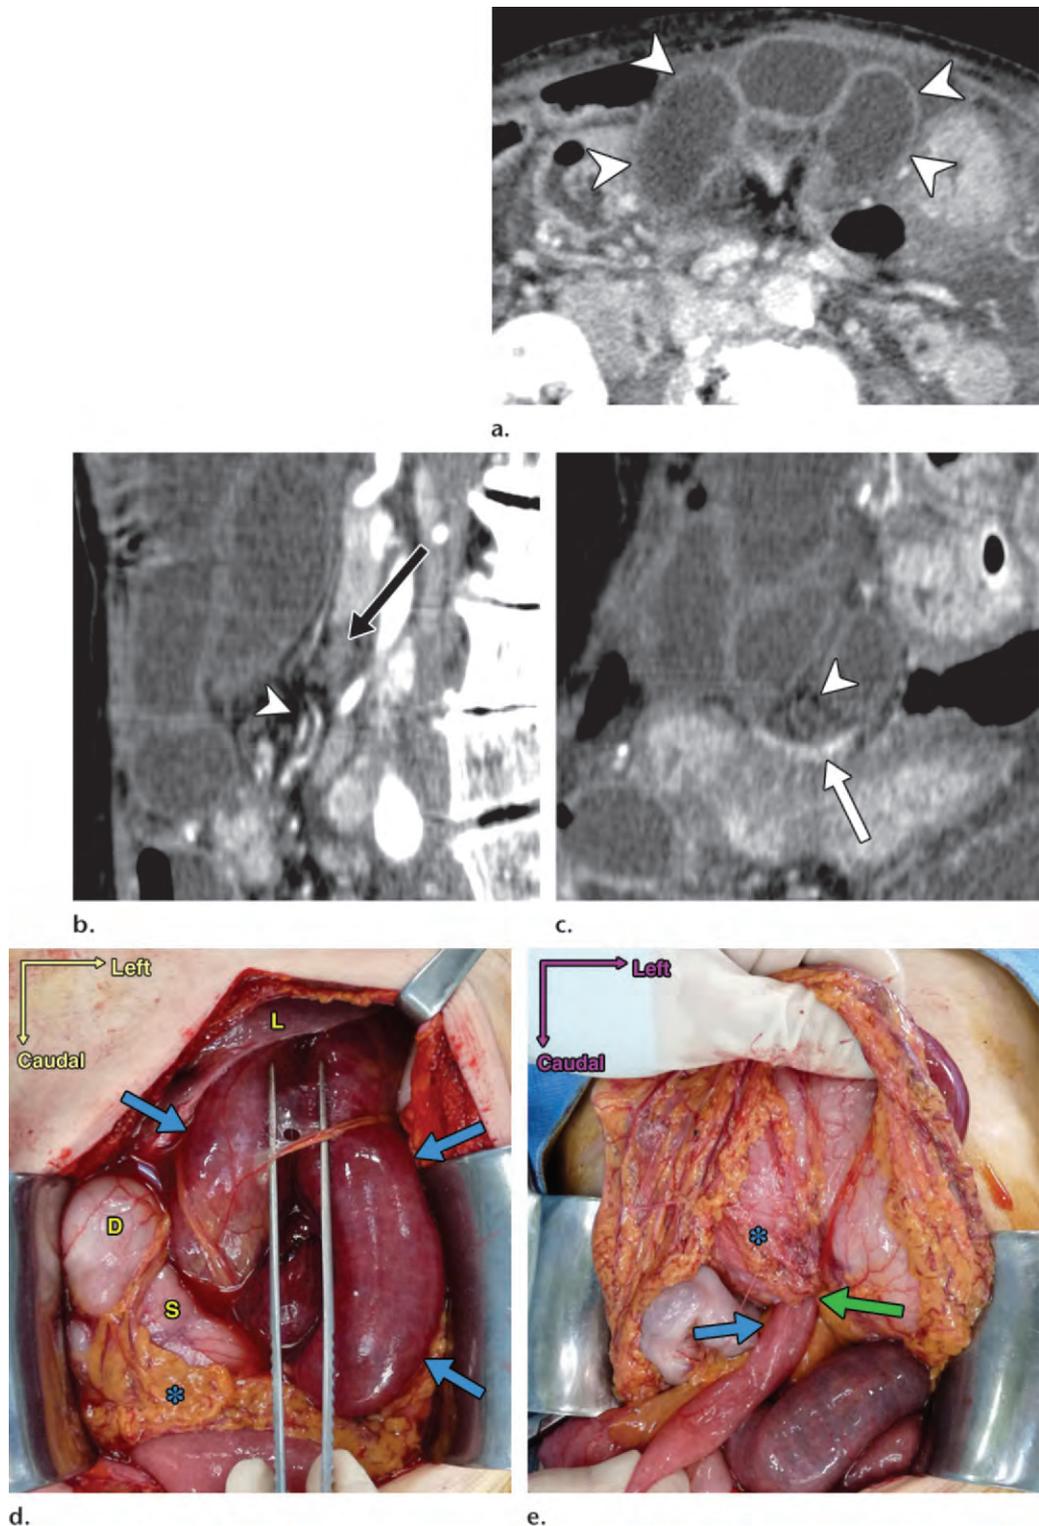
Combined lesser sac hernia through the greater and lesser omenta in a 75-year-old woman who presented with epigastric pain. (a) Axial contrast-enhanced CT image shows closed-loop intestine (arrowheads) in the anterior portion of the peritoneal cavity. (b, c) Oblique MPR CT images show the hernia orifice (arrowhead) below the transverse colon (black arrow in b) and above the right gastric vein (white arrow in c). (d) Intraoperative photograph (anterior view) shows incarcerated intestine (blue arrows) in front of the lesser omentum. * = anterior leaf of the greater omentum, *D* = duodenum, *L* = liver, *S* = stomach. (e) Intraoperative photograph (anterior view) with the greater omentum reflected shows the small intestine (blue arrow) entering a defect (green arrow) in the posterior leaf of the greater omentum (*). Approximately 60 cm of herniated intestine was seen to be dilated and congestive but not infarcted, and resection of the herniated intestine was not performed. The greater omentum was sectioned, and the defect in the lesser omentum was closed. (Case courtesy of Atsuo Imagawa, MD, Bell Land General Hospital, Sakai, Japan.)
